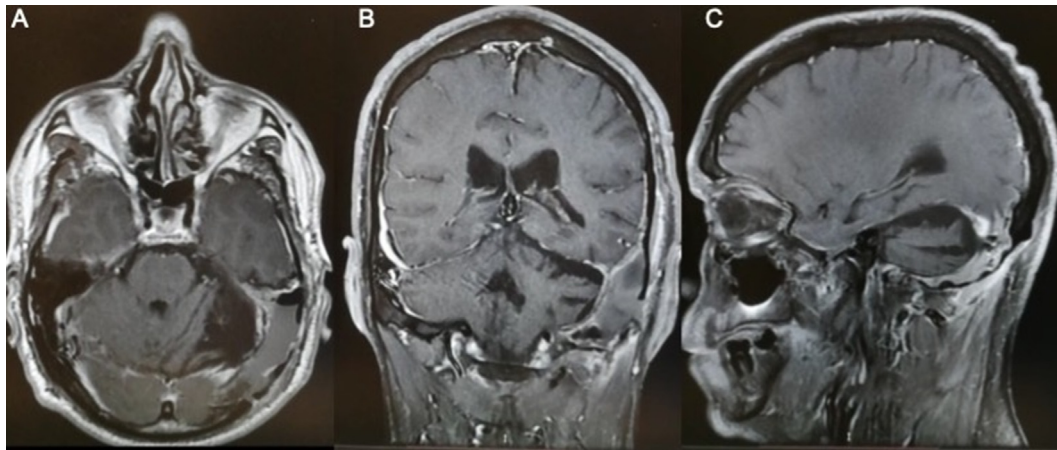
Postoperative MRI after surgery with axial (A), coronal (B), and sagittal (C) perspectives. We found no detectable residual tumor.
